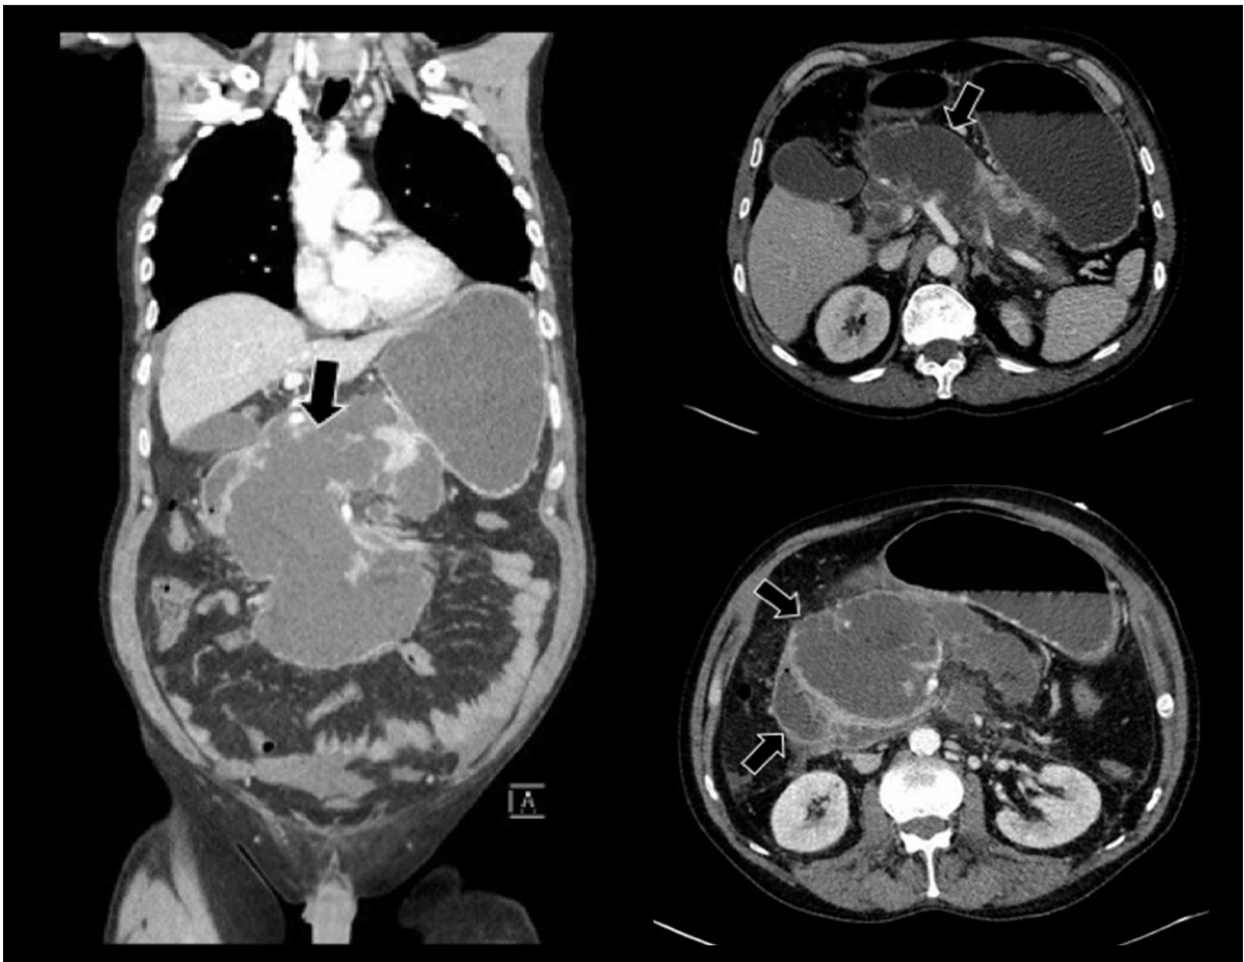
Computed tomography (CT) imaging of the abdomen with intravenous contrast shows an acute necrotic fluid collection associated with necrotizing pancreatitis. A large multiloculated collection of peripancreatic fluid is shown that has not significantly changed from the previous imaging with magnetic resonance cholangiopancreatography (MRCP). The black arrows show the pancreas with reduced enhancement and a surrounding fluid collection.
